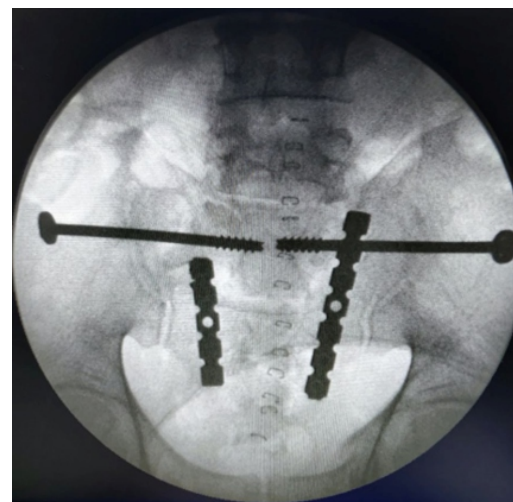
Postoperative anteroposterior intra-operative radiograph showing fixation of the fracture with two 3.5 mm reconstruction locking plates and two 6.5mm cannulated cancellous screws.
